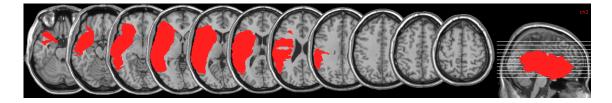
CT images for patient LH overlaid on a standard brain.
